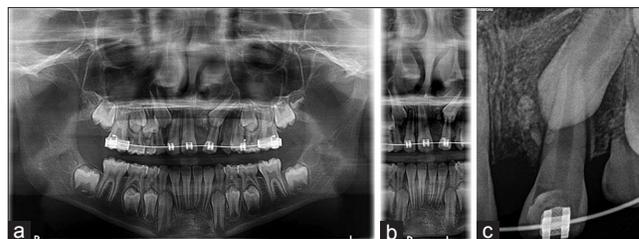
Ten-month postoperative radiographs: (a) orthopantomogram, (b) two-dimensional orthopantomogram, and (c) periapical X-ray
